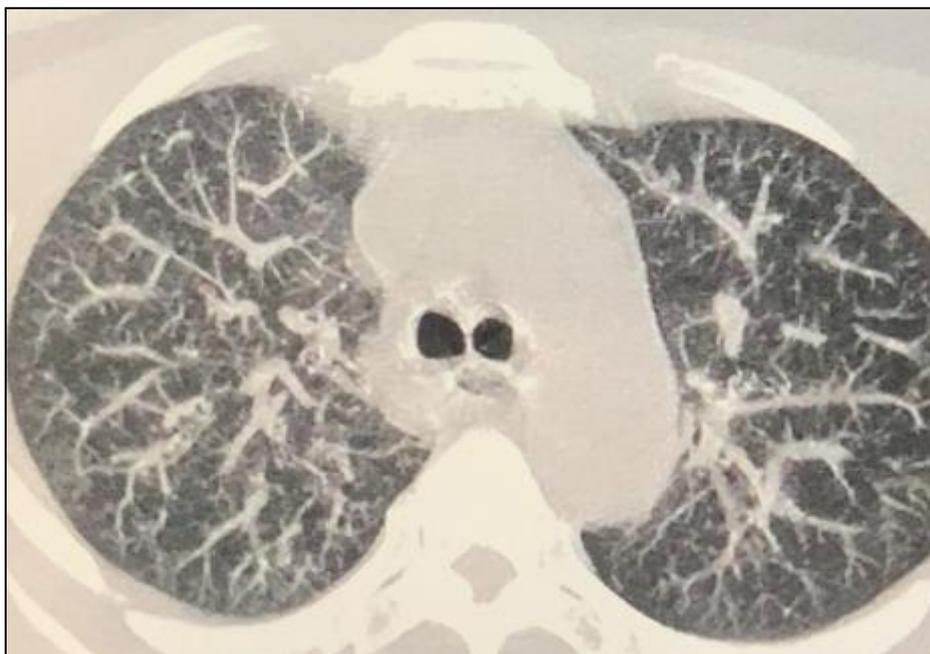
CT scan section showing a peri lymphatic distribution of micronodules, typical of sarcoidosis
